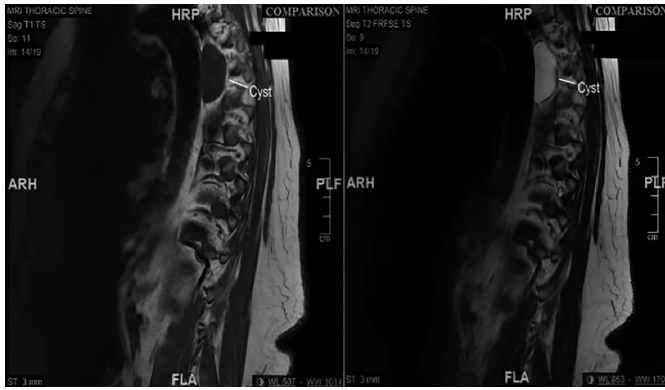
Hypointense appearance of the parasternal cyst in T1-weighted MRI (left) and hyperintensity in T2-weighted MRI (right) indicative of cystic lesion.
